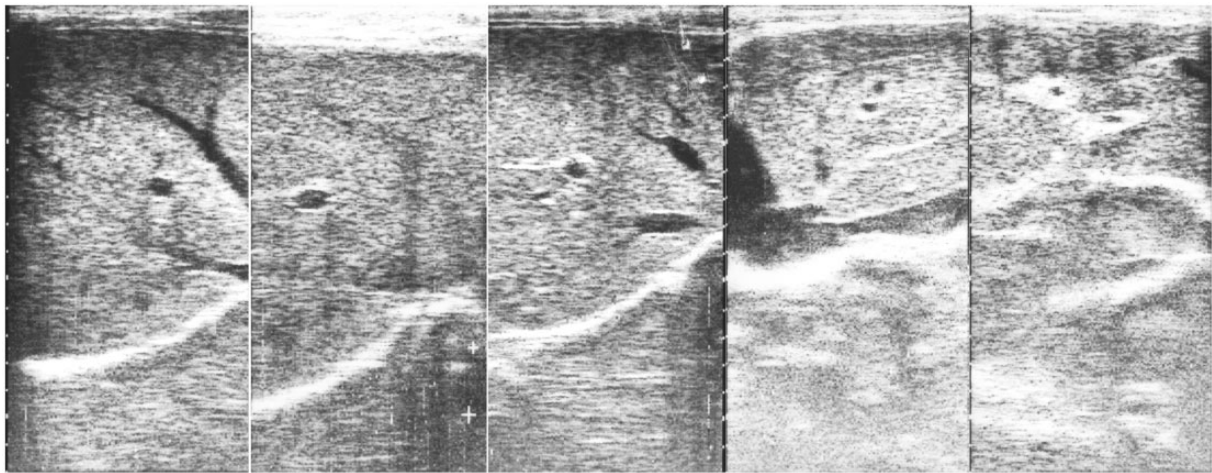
Varying appearance of portal space as seen at ultrasonography in a population survey.
